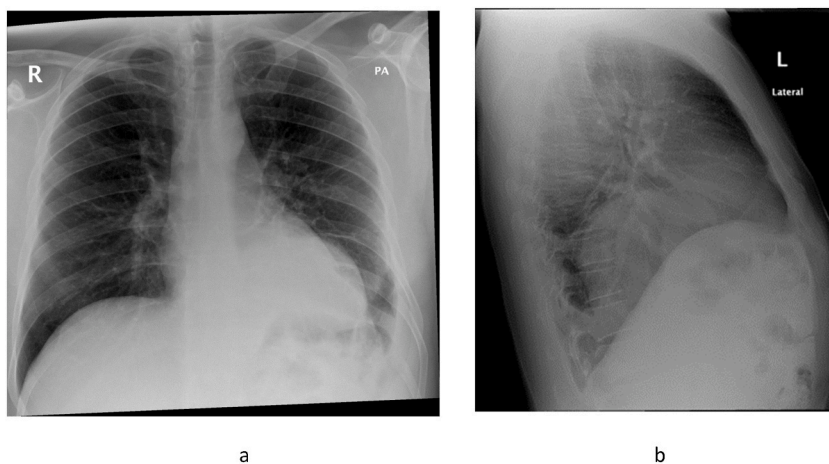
Chest radiograph in posteroanterior and lateral views: shows a poorly defined left diaphragmatic copula with retrocardiac shadow. Opacification of the left lower lung zone shows an internal air column continuing with abdominal gases, suggestive of a left diaphragmatic hernia.
